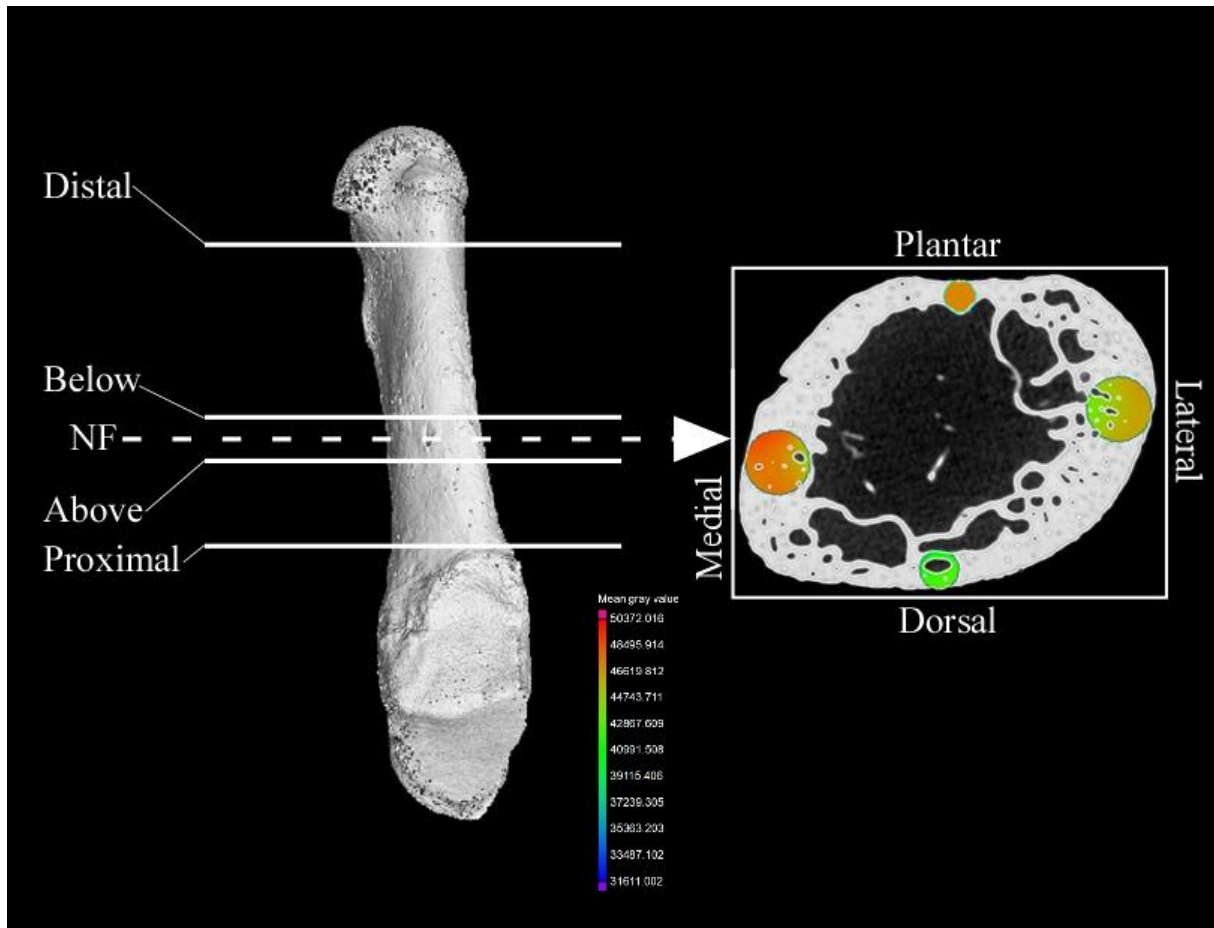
A μ CT photograph of the fifth metatarsal bone showing the medial surface and the levels of the bone where the transverse slices were taken. The dashed lines pass through the nutrient foramen level, and the arrowhead points at the insert box, showing the selected regions of interest on each surface of the bone. The coloured circled areas represent different regions of interest of the trabeculated bone with different local bone densities. NF= Nutrient foramina, Above= the area above the nutrient foramina, Below= the area below the nutrient foramina.
